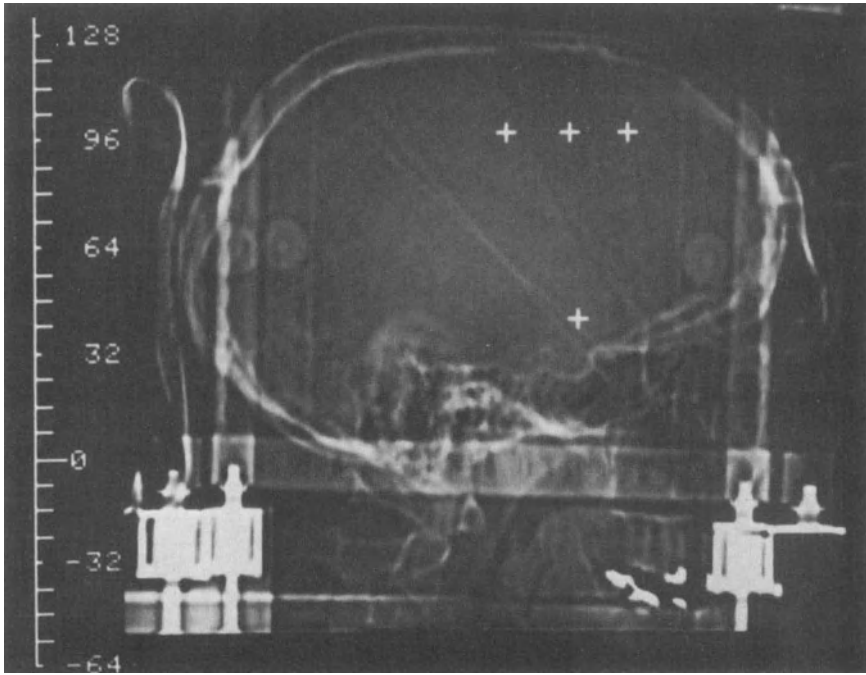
Three potential converging probe pathways are displayed at the cortical entry site, (A), level of the lateral ventricles, (B), just superior to the target, (C), and at the target, (D). The actual stereotactic frame coordinates are displayed on the CT image (cf. [12]).
